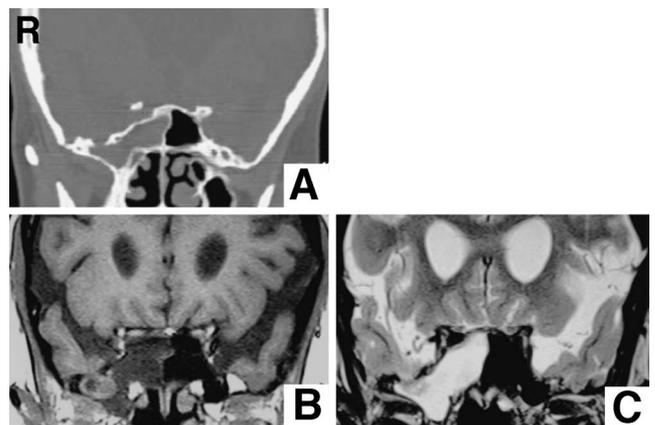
A: Preoperative coronal bone window computed tomography scan revealing a defect in the far lateral side of right middle cranial fossa and lateral extension of the sphenoid sinus. B: Coronal T₁-weighted magnetic resonance image revealing the temporal lobe herniating into the right sphenoid sinus. C: Coronal T₂-weighted magnetic resonance image revealing cerebrospinal fluid collection in the right sphenoid sinus.
